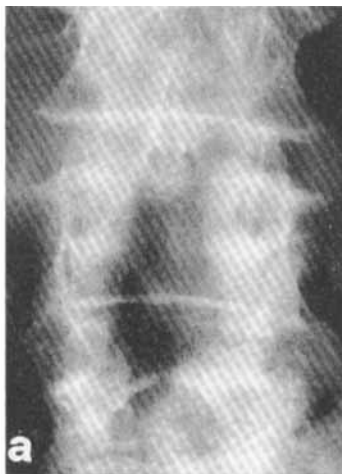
Early postoperative radiograph (a). Radiograph taken 7 years after surgery (b), showing marked regrowth of the posterior vertebral arch.
